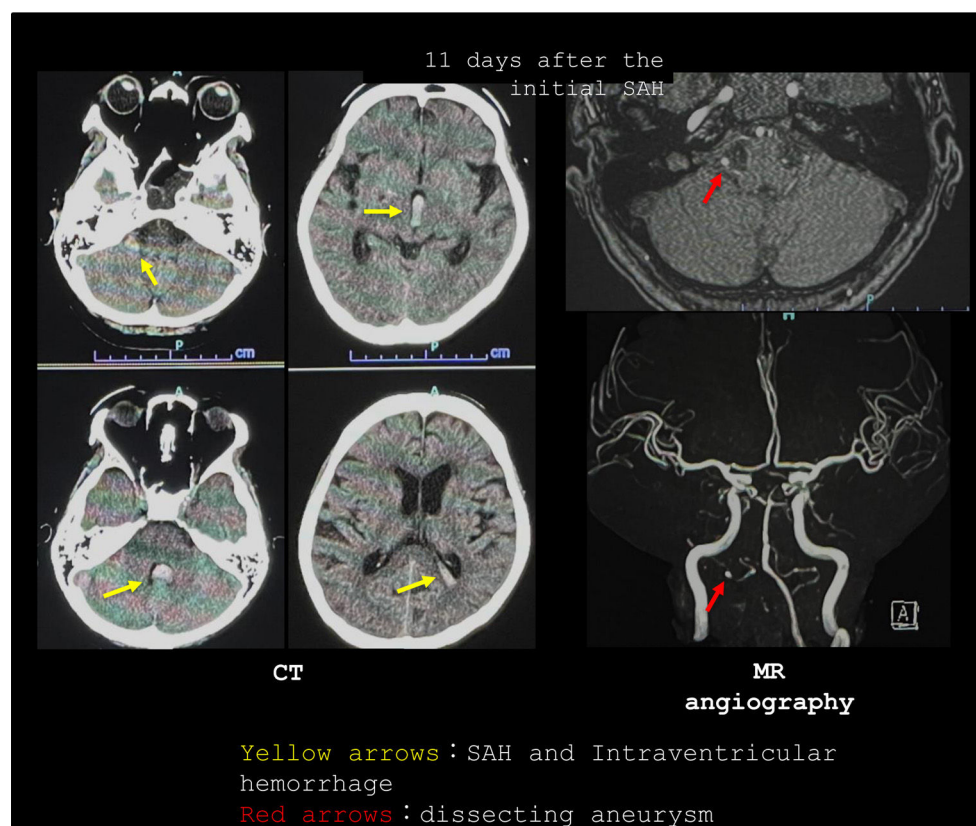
Pre-operative diagnostic imaging. CT shows subarachnoid hemorrhage and intraventricular hemorrhage. MR angiography and source axial images acquired 11 days after the initial SAH show a pearl and string sign, indicating a dissecting aneurysm. CT: computed tomography, MR: magnetic resonance, SAH: subarachnoid hemorrhage.
